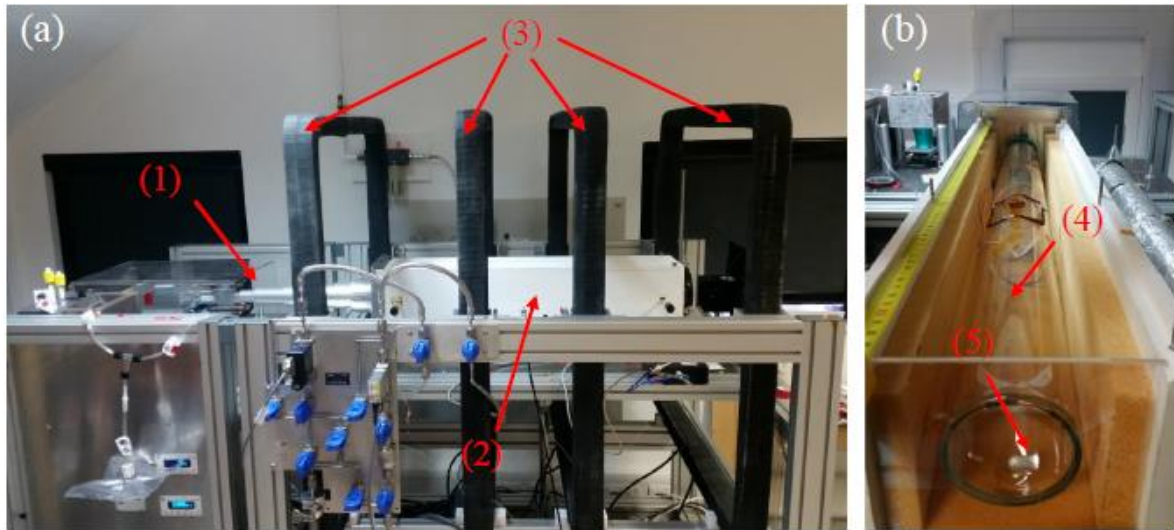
Photo of ^{129}Xe spin-exchange optical pumping polarizer, with permission [117]. (a) The photo of ^{129}Xe spin exchange optical pumping polariser used in the Sheffield MRI facility. (1) Laser diode (170 W, 794.77nm wavelength) (BrightLock 200W, QPC, CA, US); (2) The temperature-controlled ceramic oven. (3) Coils to generate the B_0 field. (b) Ceramic oven with the lid off. (4) SEOP cell (Volume = 3500 ml, 7.5 cm diameter, 80 cm length); (5) the pool of rubidium is visible at the cell gas entrance. Gas mixture used throughout 3% Xe, 87% He, 10% N₂. ©University of Sheffield.
